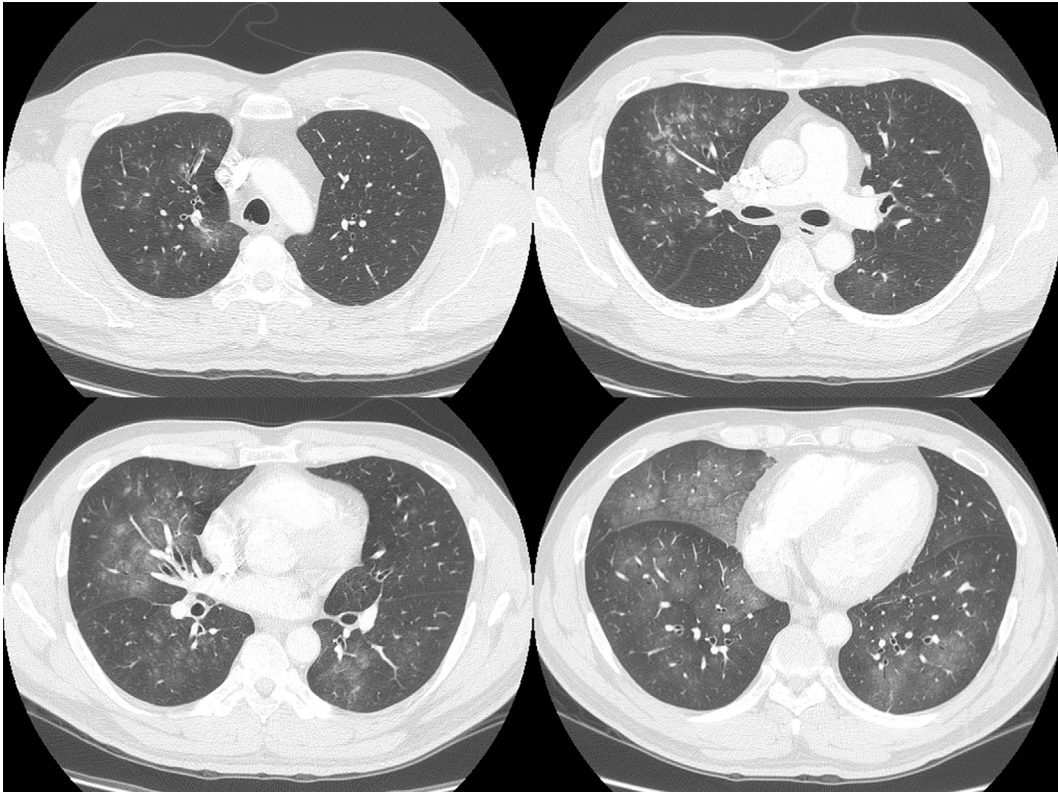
Chest computed tomography at the time of the first admission showed diffuse ground-glass opacity in the bilateral lung fields.
